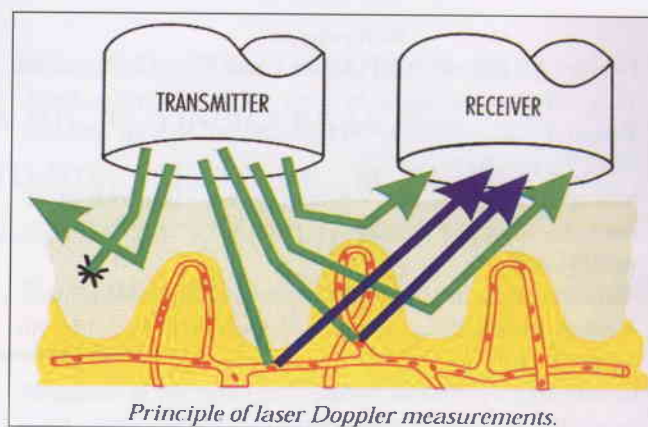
Laser Doppler can measure skin capillary flow.
